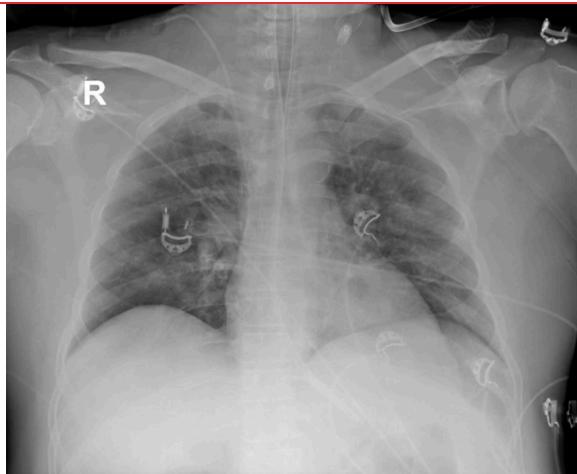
Chest X-ray showing multiple bilateral ground-glass opacities.
